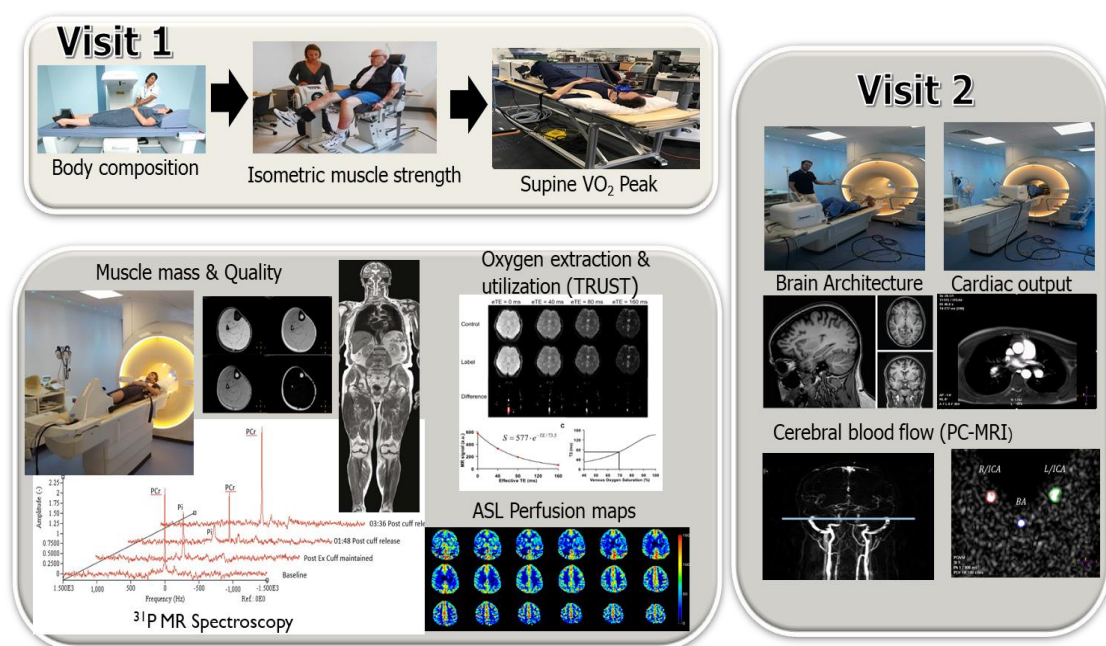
Overview of experimental study visits comprising: Visit 1 in the David Greenfield Human Physiology Unit to perform functional phenotyping and Visit 2 at the Sir Peter Mansfield Imaging Centre to collect ^{31}P MRS and ^1H MRI of healthy volunteers and quiescent Crohn's disease patients.
